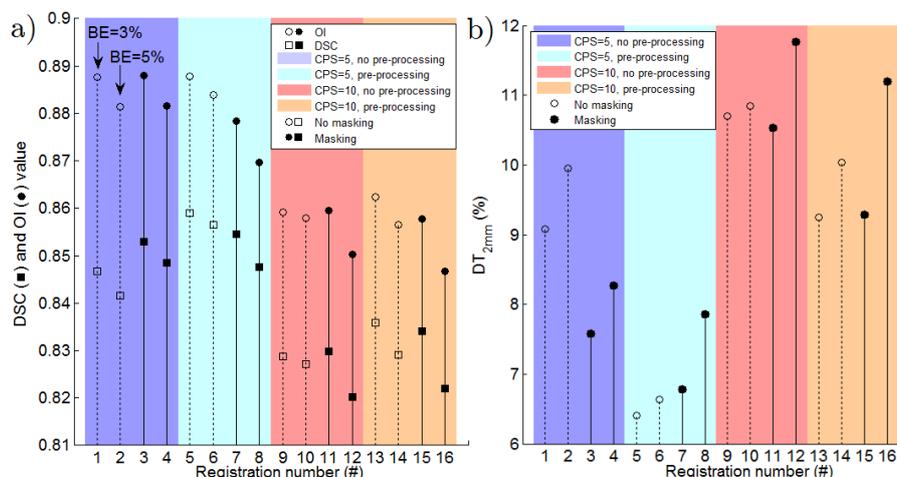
Variation of a) DSC (squares) and OI (circles) and b) DT_{2mm} for different combinations of parameters: BE=3% (#1,3,5,7,9,11,13,15) and BE=5% (#2,4,6,8,10,12,14,16); CPS=5 (#1-8) and CP=10 (#9-16); mask (#3,4,7,8,11,12,15,16) and no mask (#1,2,5,6,9,10,13,14); pre-processing (#5-8,13-16) and no-preprocessing (#1-4,9-12). Smaller control point spacing translated in larger values of DSC and OI. Pre-processing the CBCT improved DSC and DT_{2mm} values.
